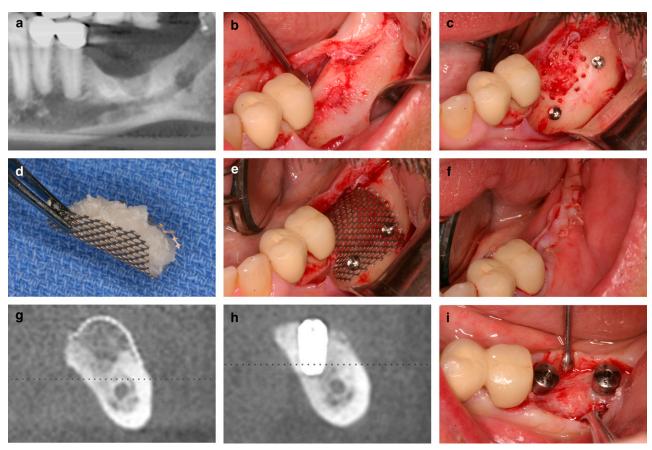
Case 2. 2a A preoperative radiograph of the left posterior mandible revealed a vertical bone defect. 2b A mucoperiosteal flap was reflected to expose the defect. 2c The cortex over the defect site was perforated to allow access to the intramedullary stem cells. 2d The titanium mesh was contoured over the defect and filled with the mixture of rhBMP-2/ACS and mineralized bone allograft. 2e The titanium mesh was fixated with monocortical screws. 2f Tension-free primary closure of the flaps over the graft site. 2g A cross-sectional view of the CT scan of the mandible revealed the regenerated bone under the titanium mesh. 2h A cross-sectional view of the CT scan after implant placement. 2i Exposure of the implants for placement of healing abutments after 2 months of healing.
